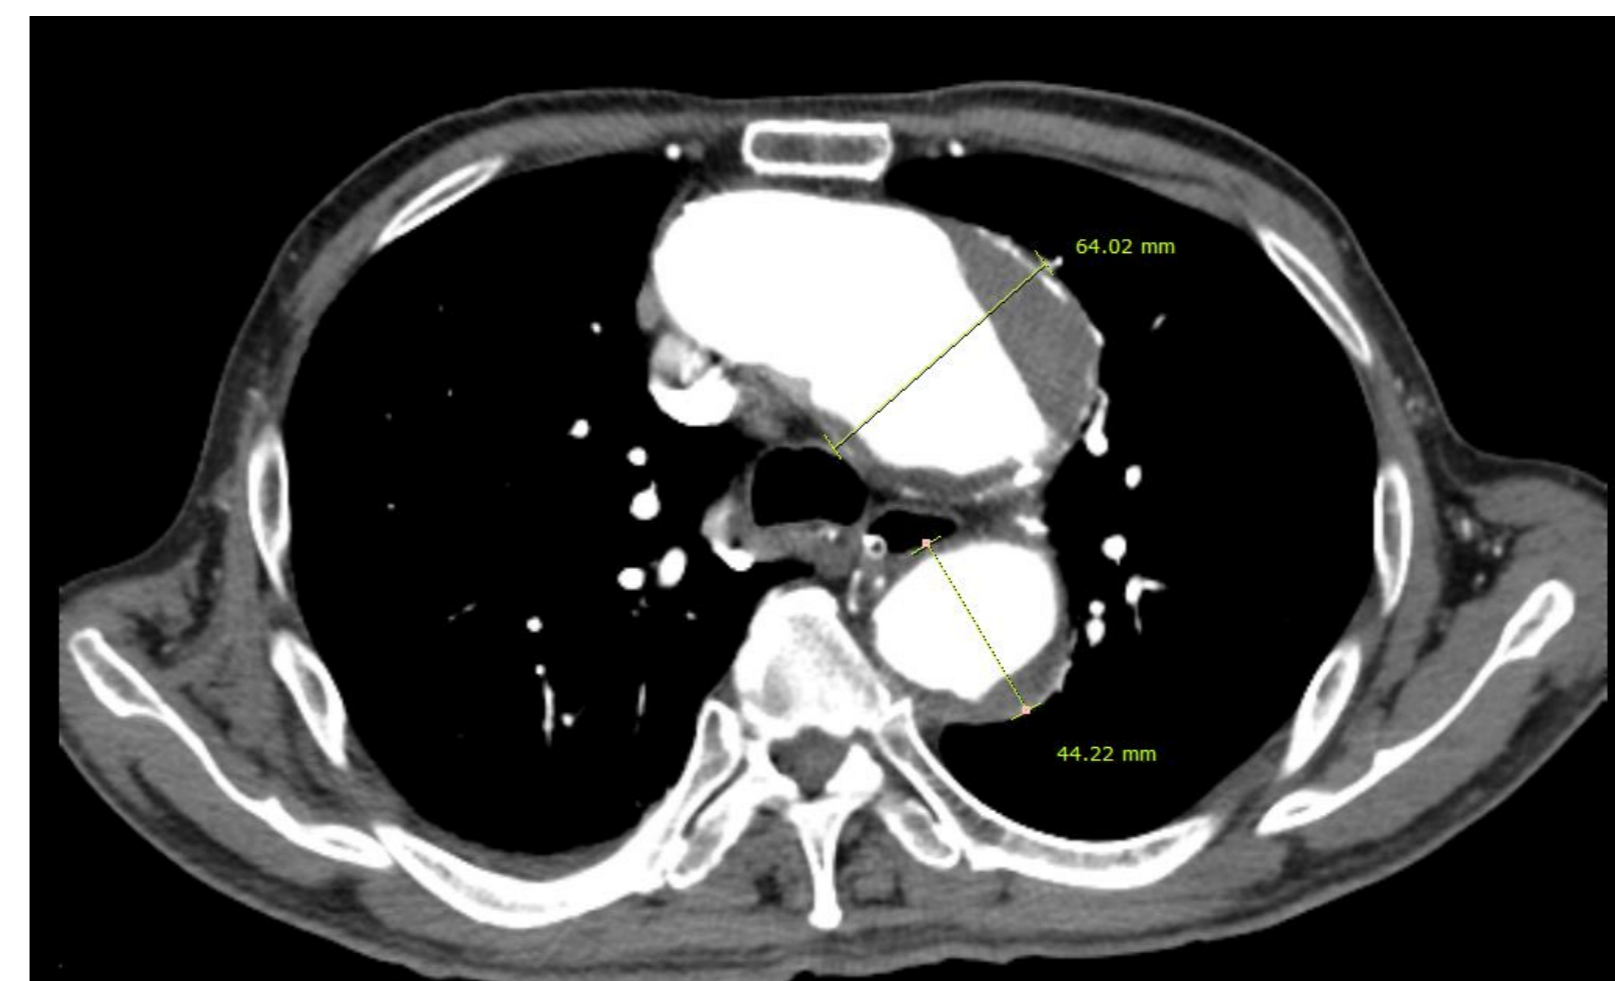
Axial CT. Aneurysmal dilation of both ascending (64.02 mm) and descending (44.22 mm) segments.
